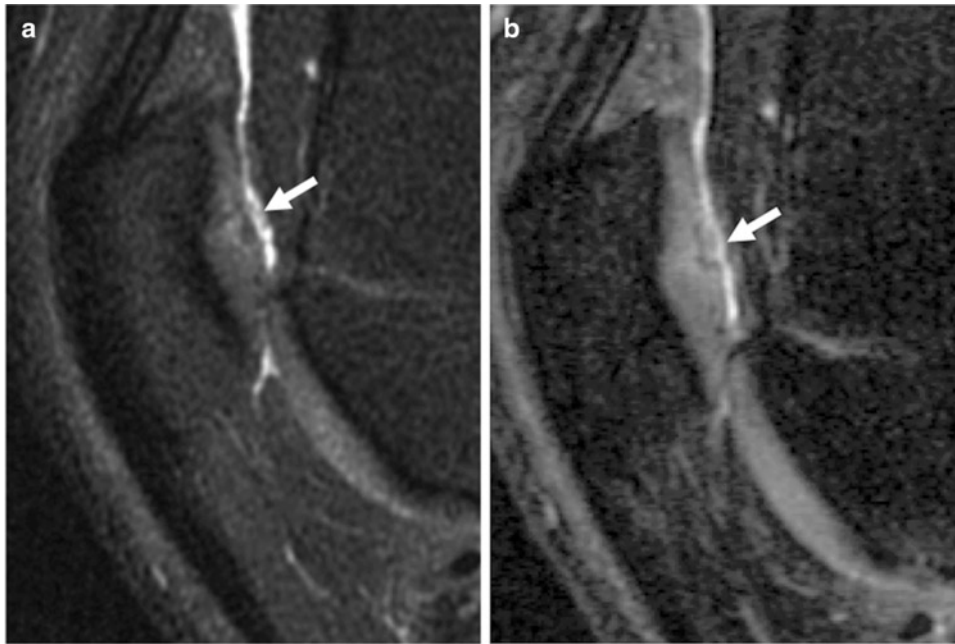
1.5 T (a) and 3.0 T (b) sagittal fat-suppressed IM-weighted FSE MRI of the patella (3,200/46 and 4,300/51 ms). Fissures at the patella (arrow) are shown in greater detail at 3.0 T and the surface of the cartilage is substantially better evaluated at 3.0 T than at 1.5 T
